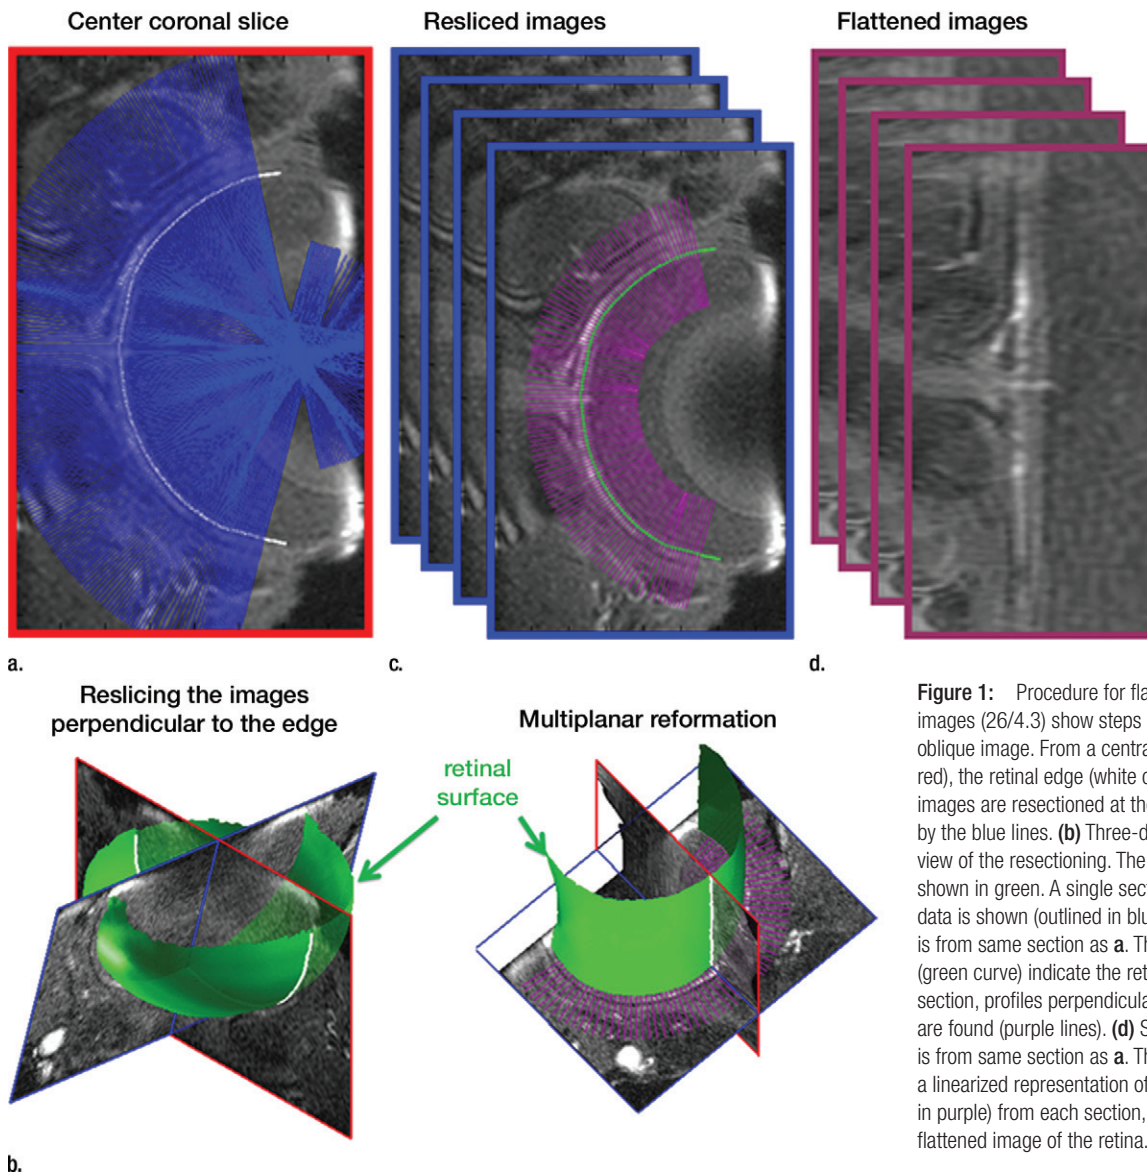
Procedure for flattening the retina. MR images (26/4.3) show steps as follows: (a) Coronal oblique image. From a central section (outlined in red), the retinal edge (white curve) is found. The 3D images are resectioned at the locations indicated by the blue lines. (b) Three-dimensional oblique view of the resectioning. The 3D retinal surface is shown in green. A single section of the resectioned data is shown (outlined in blue). (c) Oblique image is from same section as a. The resectioned data (green curve) indicate the retinal surface. From each section, profiles perpendicular to the retinal surface are found (purple lines). (d) Spatially warped image is from same section as a. The profiles produce a linearized representation of the retina (outlined in purple) from each section, resulting in a 3D flattened image of the retina.
